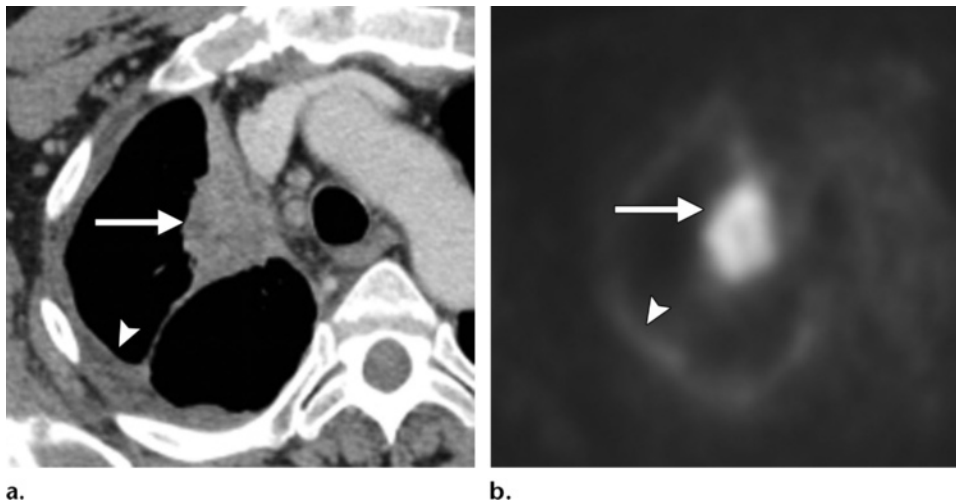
Pleural metastasis. (a) Chest CT scan shows a right upper lobe mass (arrow) abutting the mediastinum, along with pleural thickening and effusion (arrowhead). (b) Axial FDG PET scan shows radiotracer uptake in the right upper lobe mass (arrow) and ipsilateral pleura (arrowhead). At thoracentesis, the pleural effusion proved to contain malignant adenocarcinoma cells from the primary tumor in the right upper lobe (cf a).
